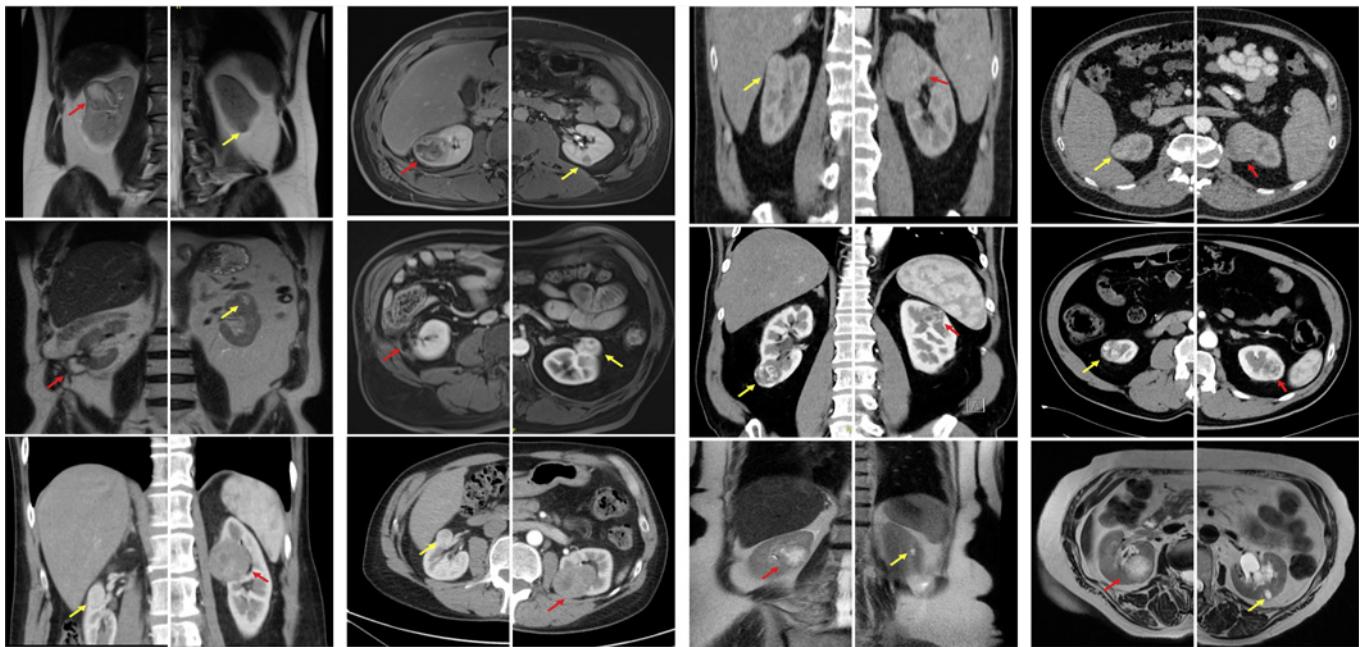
CT/MRI scans of all patients in the cohort. The red arrows indicate the tumors treated with OPN, and the yellow arrows indicate the tumors treated with RAPN.
